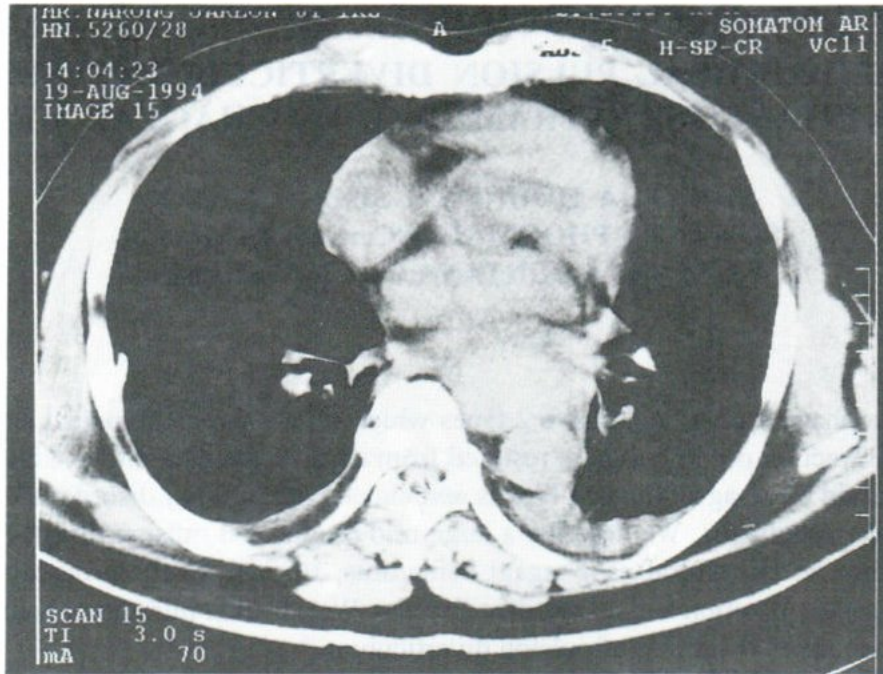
CT scan on the first day of admission showed a large intramural esophageal hematoma at mid esophagus and bilateral pleural effusion.
